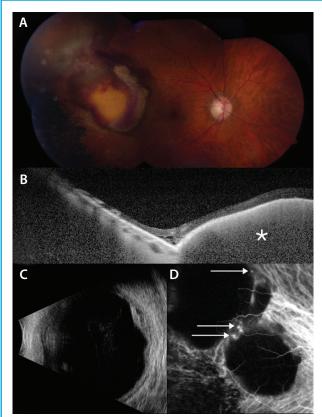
Abruptly elevated hemorrhagic lesion located in temporal quadrant with inferior pigmentary changes. The red, yellow, and gray areas represent different stages of subretinal and sub-RPE hemorrhage (A). OCT demonstrated the abruptly elevated RPE detachment, indicated with an asterisk (B). B-scan ultrasonography OD showed an elevated lesion measuring 3.3 mm with heterogeneous acoustic reflectivity (C). ICGA demonstrated multiple polyp-like hypercyanescent foci (arrows) adjacent to two areas of blocked cyanescence representing hemorrhage (D).
